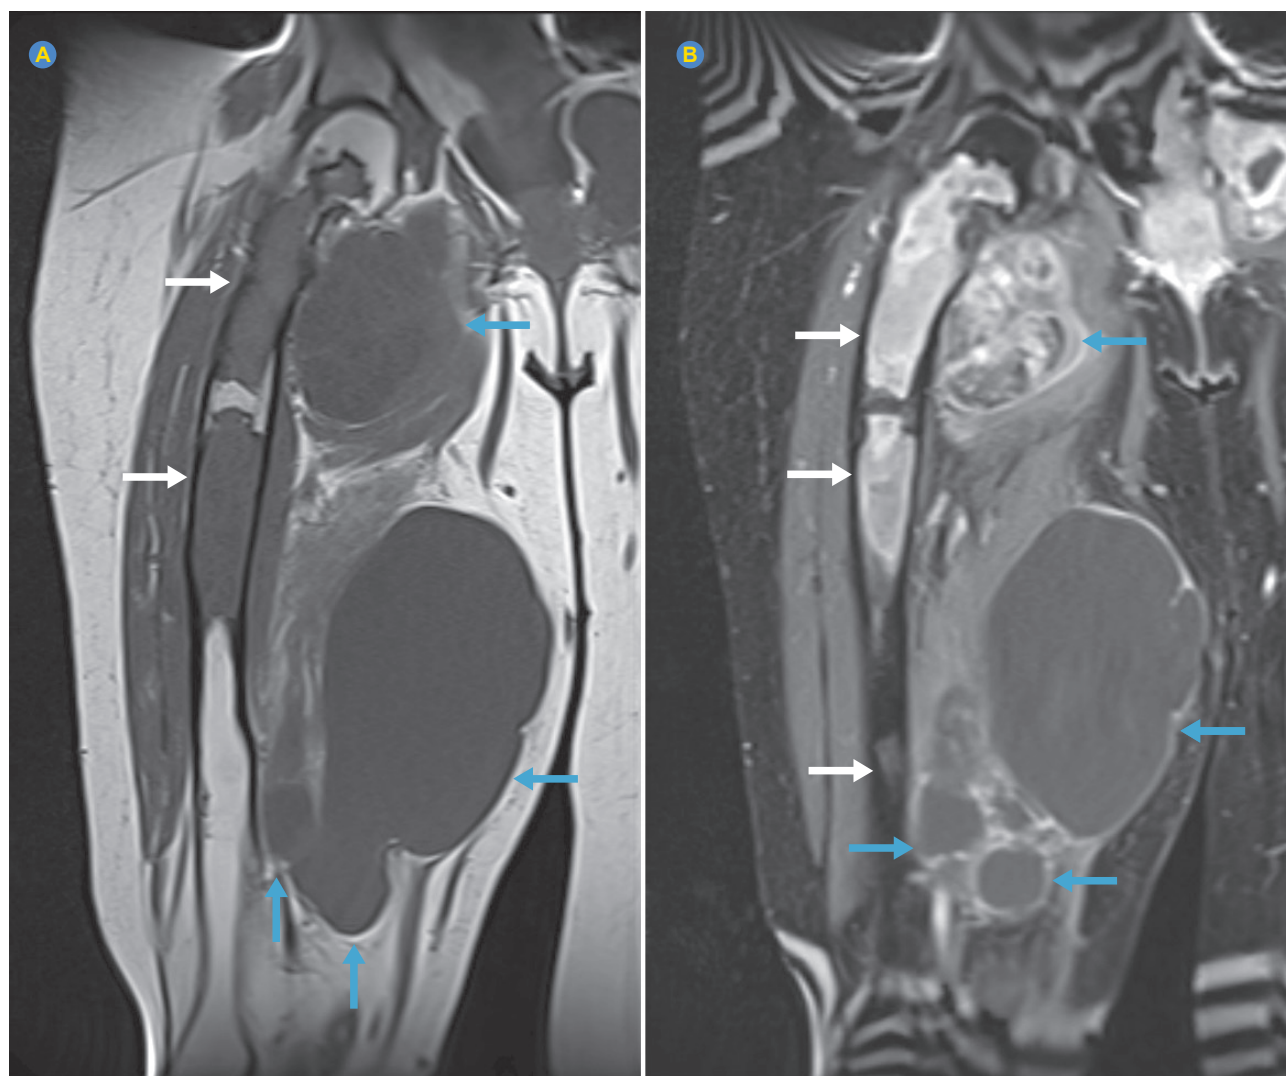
T1 weighted-image MRI in coronal section (A); T1 FAT SAT DIXON with contrast weighted-image MRI in coronal section (B). MRI revealed extensive heterogeneity of the femur with an expansile appearance, significantly affecting its proximal portion, with heterogeneous contrast enhancement, in a 'cane-shaped' configuration, consistent with fibrous dysplasia (white arrows). Multiple lobulated intramuscular images with peripheral contrast enhancement and others with heterogeneous contrast enhancement, consistent with intramuscular myxomas (blue arrows).
